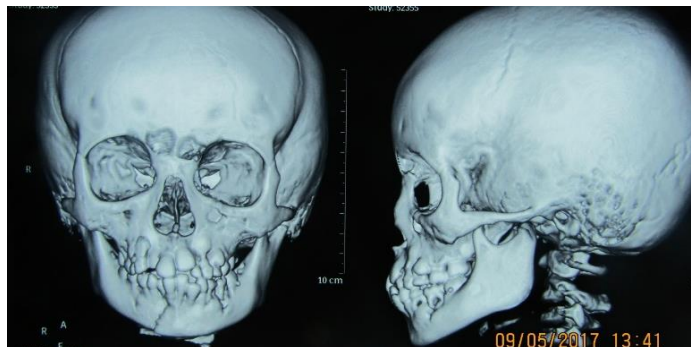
Clinical photo and CT scan of the first patient
